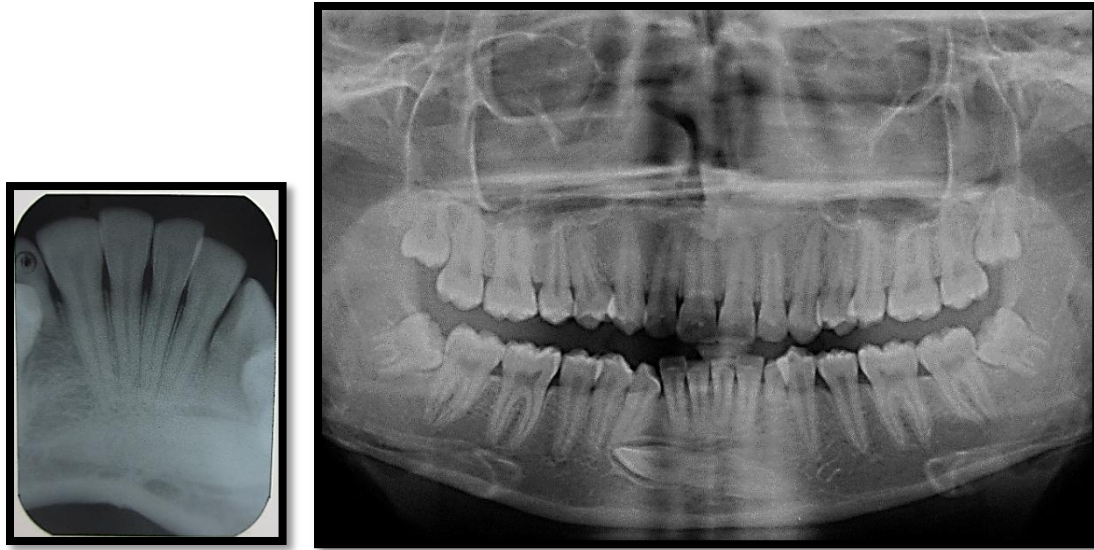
Intraoral periapical radiograph and panoramic radiograph showing Well-defined, corticated, radiolucent tract extending from crown of impacted tooth to location of normal eruption site at alveolar crest.
